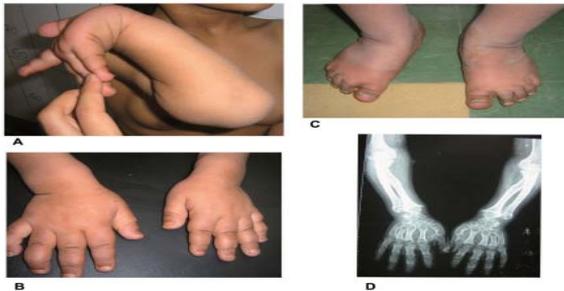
Case 16 with SEMDJL at 14 years of age. Right upper limb showing hyperextensibility of wrist and interphalangeal joints (A). Hands with brachydactyly and spatulate ends of distal phalanges (B). Short broad feet with short toes and broad big toes (C). X-ray (PA view) of forearms and hands showing irregular long bones, radius overriding head of humerus, flaring of metaphyses and short metacarpals (D)
